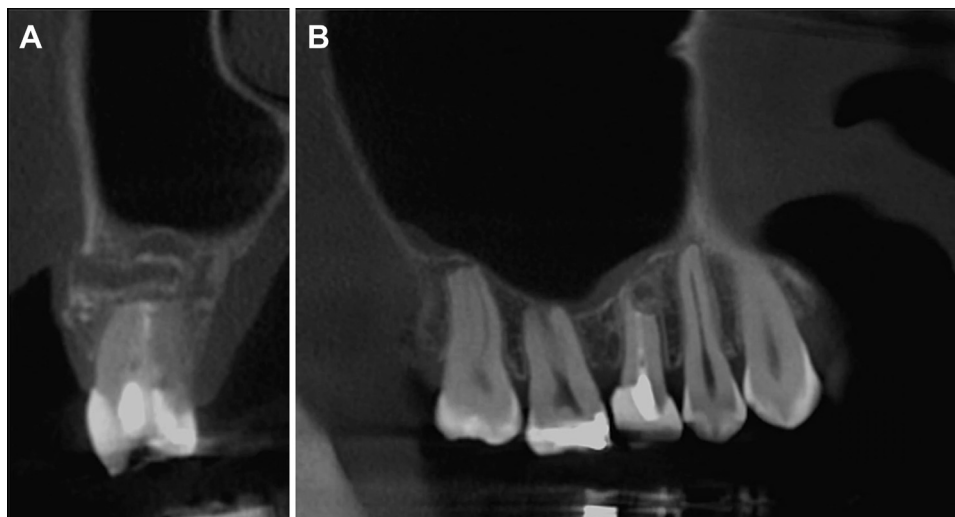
A, B, One-month follow-up cone-beam computed tomography images showing selective tissue removal and absence of any damage to sinus bone wall.
